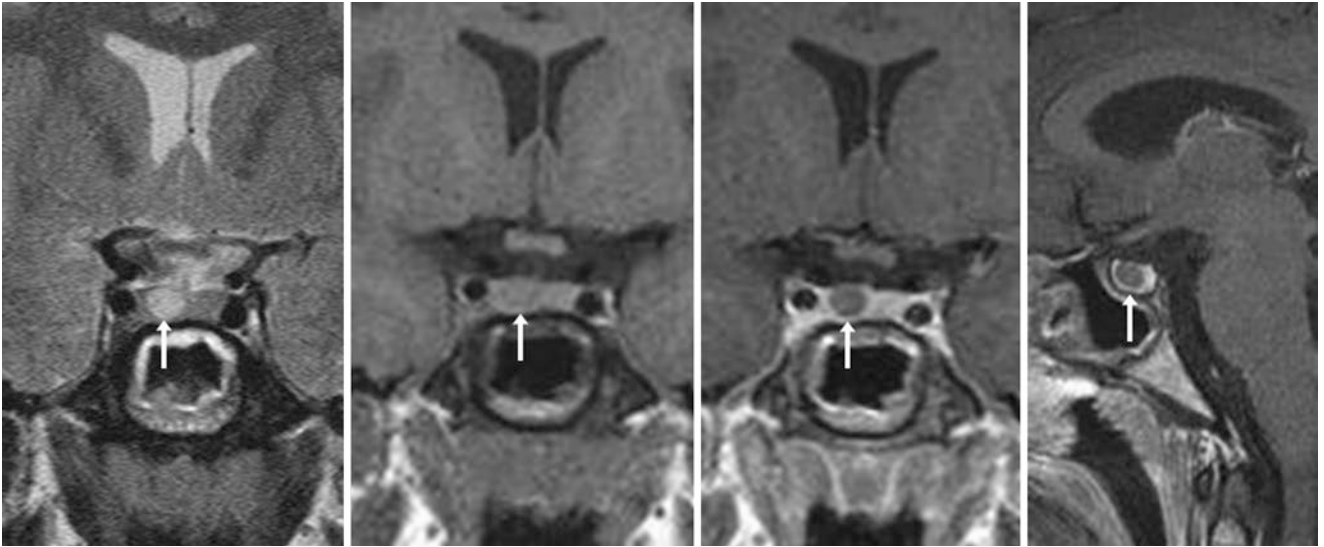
The patient was a 21-year-old female with headaches and weight gain. A 1.5 T MRI noted a 6-mm T1-isointense (to gland) RCC (arrows) within the gland but lateral to the stalk on coronal T2WI (left), on precontrast T1WI (left middle), on postcontrast T1WI (right middle), and on sagittal postcontrast T1WI (right)
